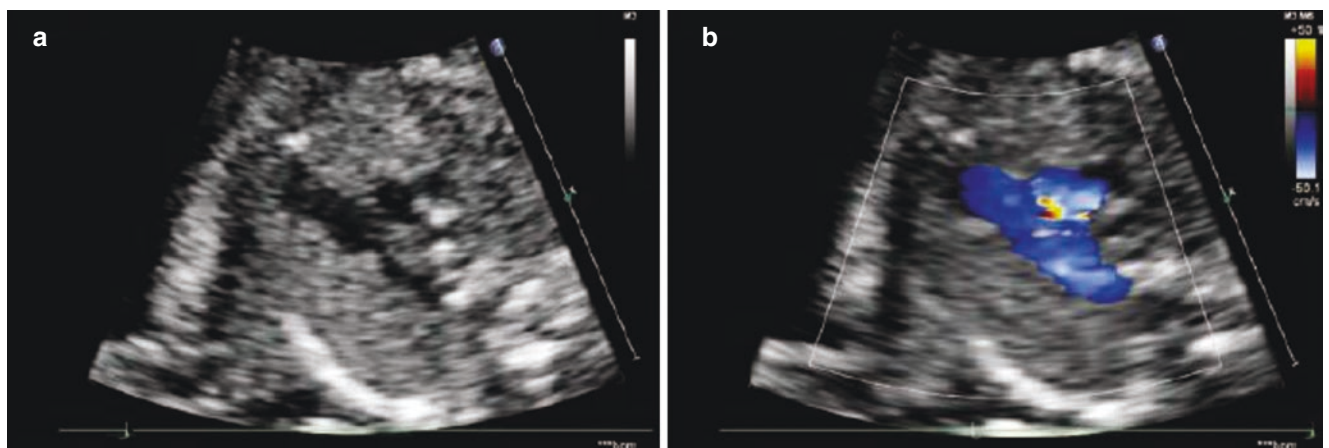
Three-vessel and trachea view and color Doppler flow imaging. (a) 2-D sonography of three-vessel trachea view. (b) Color Doppler flow imaging of three-vessel trachea view
